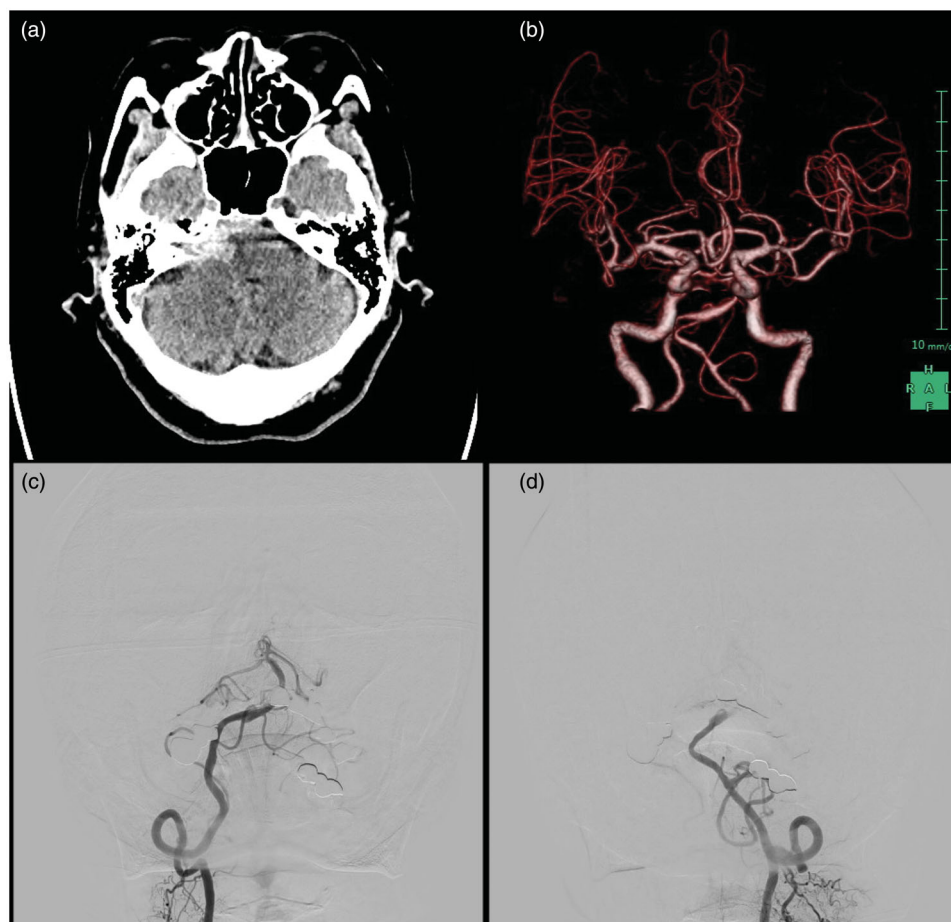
(a) Computed tomography (CT) on the day of admission shows subarachnoid hemorrhage (SAH) in the interpeduncular cistern and on the right side of the cerebellopontine angle (CPA). (b) CT angiography shows no aneurysms, dissections, or vascular malformation. Right (c) and left (d) vertebral angiography shows no abnormalities.
